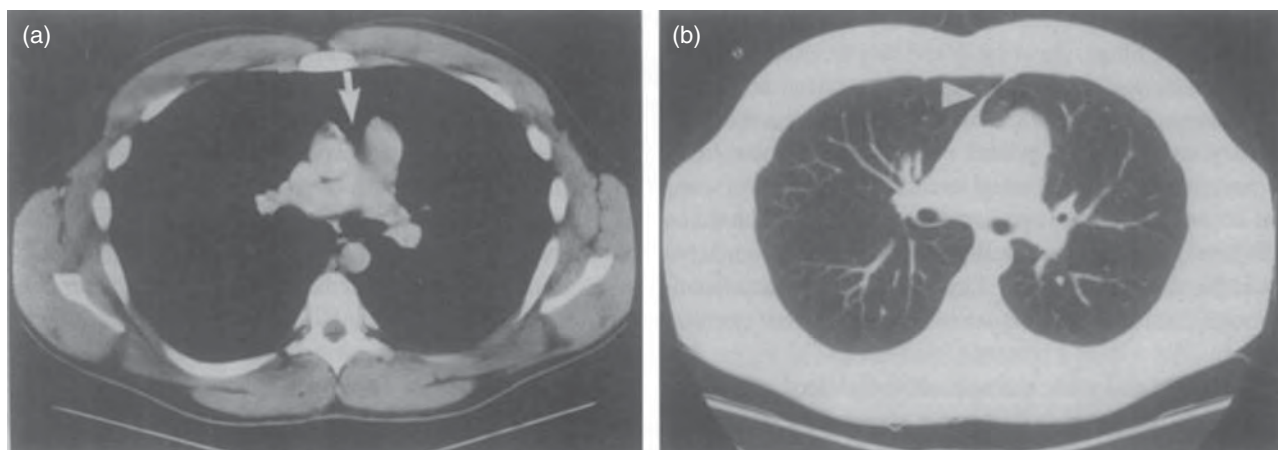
Computed tomography of the chest. (a) Scan at the level of the pulmonary artery demonstrates lung interposed between main pulmonary artery and the ascending aorta (arrow), a finding strongly suggestive of absent pericardium. (b) Lung setting at the same level demonstrates prominence of the sternopericardial ligament (arrowhead), which is evident when pericardium is absent. *Source:* Van Son *et al.* 1993 [5]. Reproduced with permission of Elsevier.
